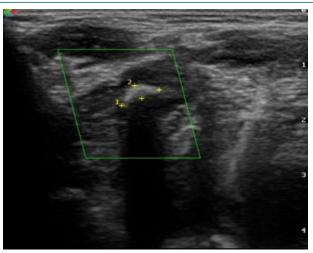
A 17 year old female with a swelling on the right side of jaw with pain during food intake which was a case of sialolithiasis seen as hyperechoic areas with distal acoustic shadowing and no evidence of vascularity on Color Doppler.
